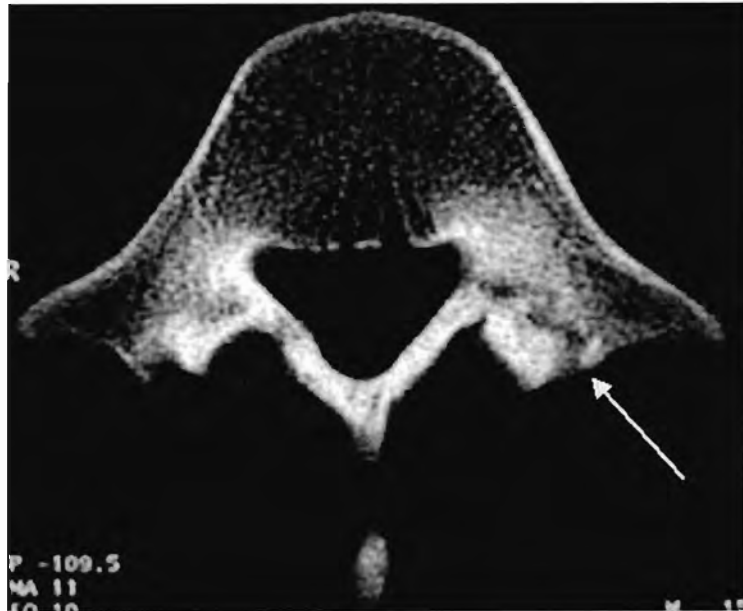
A CT scan of this 17-year-old right arm bowler (subject 10) shows a healing fracture of the left pars interarticularis of the 5th lumbar vertebra.
